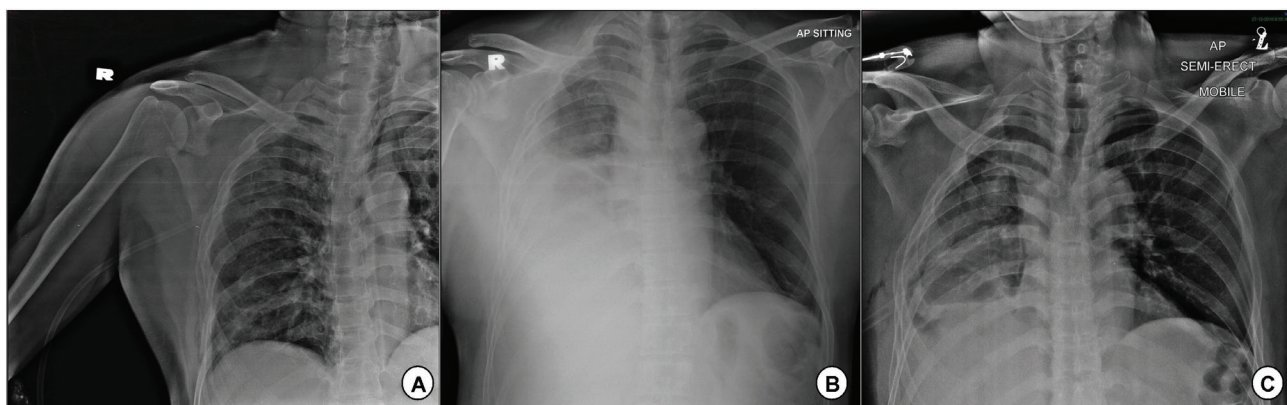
Chest radiographs. (A) The first chest radiograph following MVA showing right second to eighth rib fractures. (B) Chest radiograph taken at Day-7 post-trauma showing homogenous opacity up to the right middle zone. (C) Chest radiograph post-chest tube insertion at the Emergency Department showing signs of clearing up of the right lung field.
